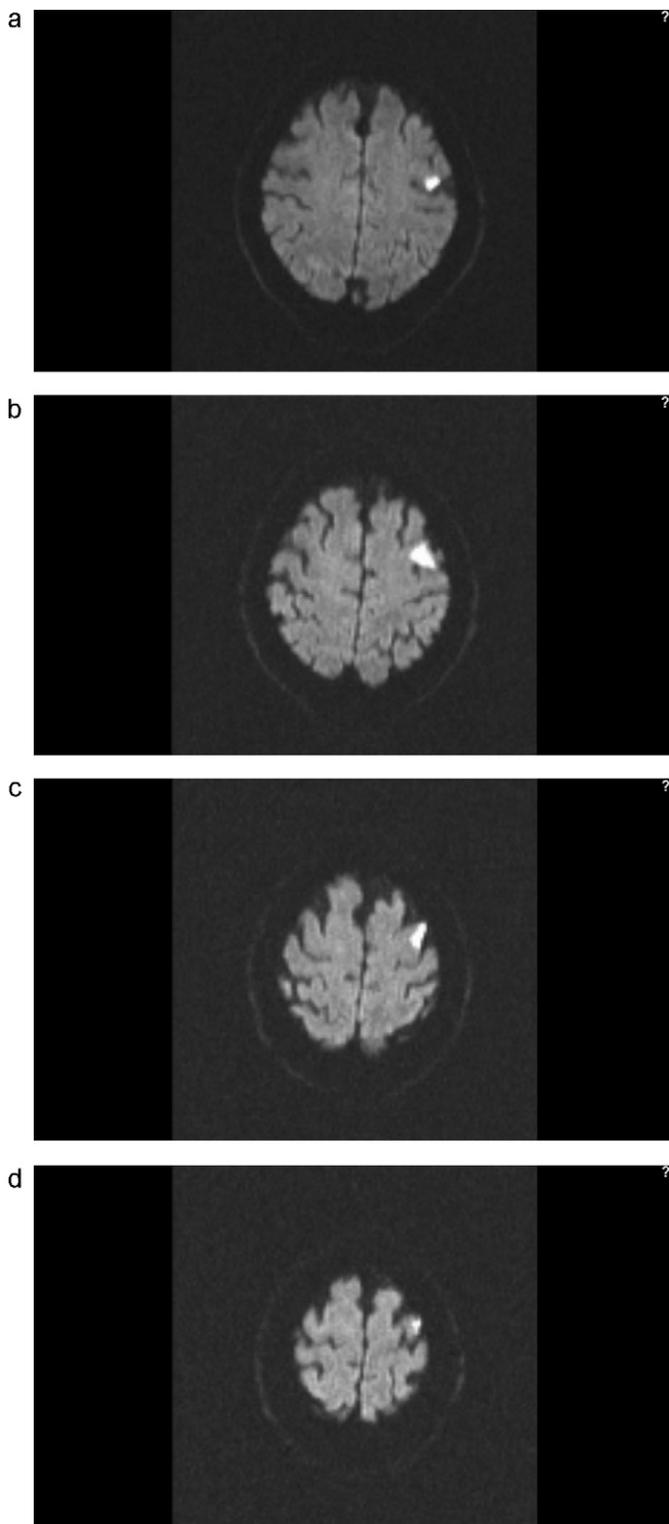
(a–d) Diffusion-weighted magnetic resonance images showing abnormal hyperintense lesion in the left medial frontal gyrus, consistent with an acute ischemic event.
